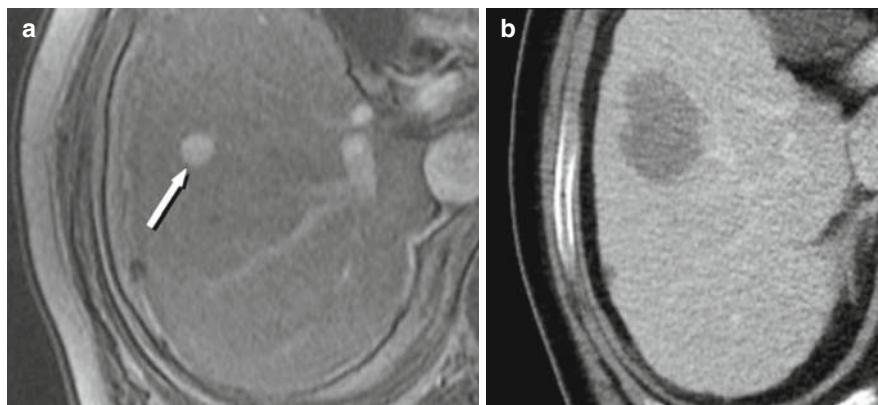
Small HCC treated with radio-frequency ablation. (a) Arterial phase MR, T1-weighted image shows a 1 cm hypervascular nodule (*arrow*). (b) Following percutaneous RF ablation under ultrasound guidance the ablation defect is shown, with no viable tumor on enhanced CT.
